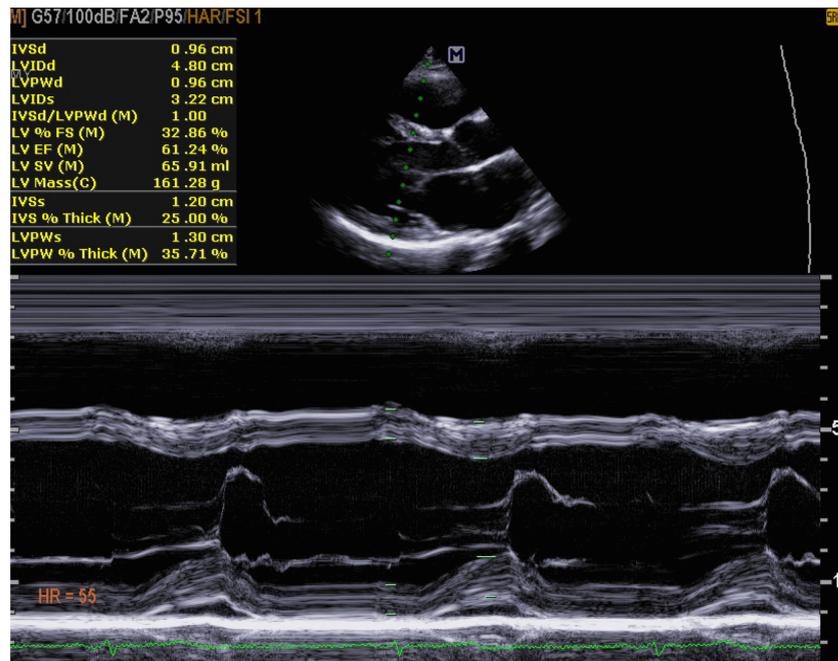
Parasternal long axis M-mode trace
